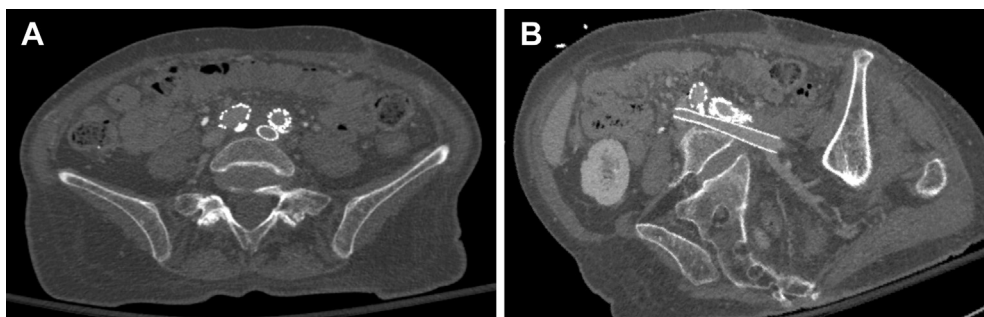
Computed tomography angiography after intervention demonstrating patent left common iliac vein stent passing underneath the left iliac limb of the bifurcated endovascular aortic aneurysm repair device (A) in the axial plane and (B) with single multiplanar reconstruction.
